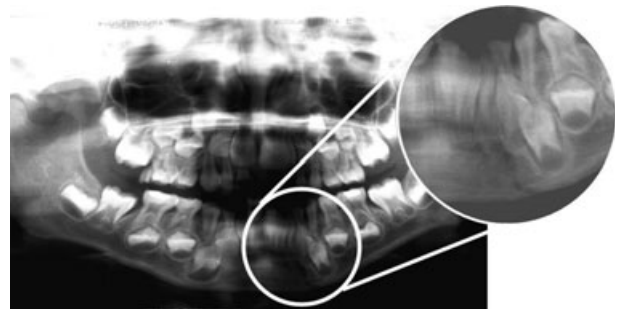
Panoramic radiograph and magnified detail. Fracture of the left parasymphiseal region.
